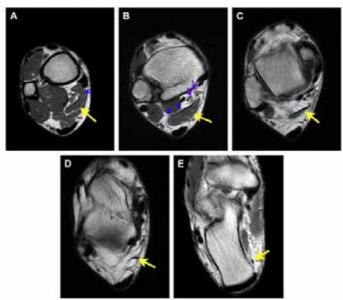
Proton-density weighted MR images in a 37 year old man with ankle pain. (A): Axial view of the ankle. (B): Proximal to plafond. (C): Tip of Medial Malleolus. (D): Tip of Lateral Malleolus. (E): Body of calcaneus. The accessory soleus muscle belly (yellow arrows) lies superficial to the deep aponeurosis (blue arrows in A and B), posterior tibial neurovascular bundle (purple arrows in A and B). Adapted from Magnetic Resonance Imaging Clinics of North America, 2017.⁴
